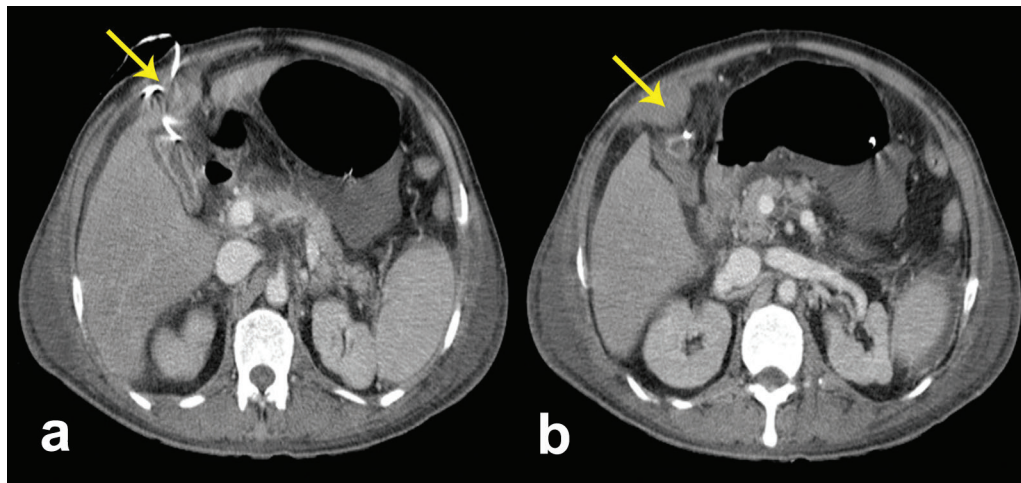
CT performed on day 3 in a patient who underwent percutaneous cholecystostomy. Arrows showing drainage tube outside the lumen of gall bladder (a) and a small parietal wall hematoma (b).
